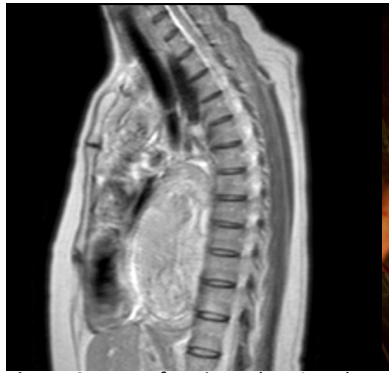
MRI of patient showing the posterior mediastinal tumor
